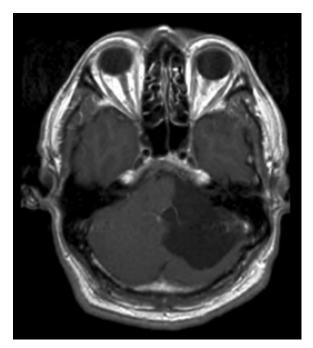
Epidermoid. A 55-year-old man complained of left-sided tinnitus and hearing loss for 2 years. He also experienced severe recurrent dizziness and chronic head-ache. Enhanced axial T1-weighted magnetic resonance imaging showed a large heterogeneous low-signal intensity tumor with no enhancement. The tumor was removed by the retrosigmoid approach.
